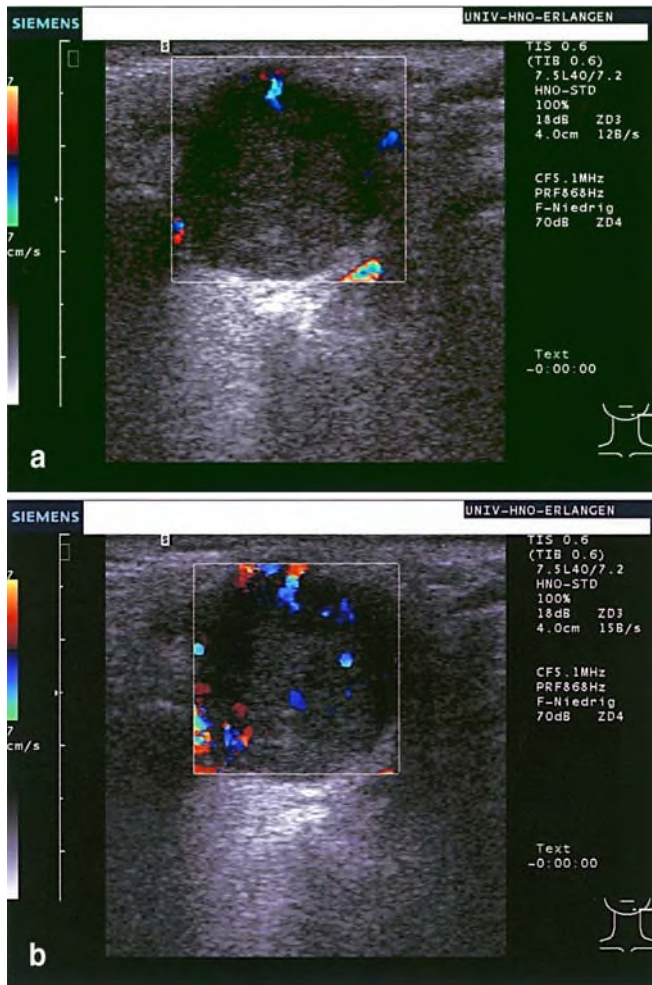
a Color Doppler image of a pleomorphic adenoma of the parotid gland with low vascularization before application of signal-enhancing agent. b Maximum color Doppler signal of a pleomorphic adenoma after application of enhancing agent
